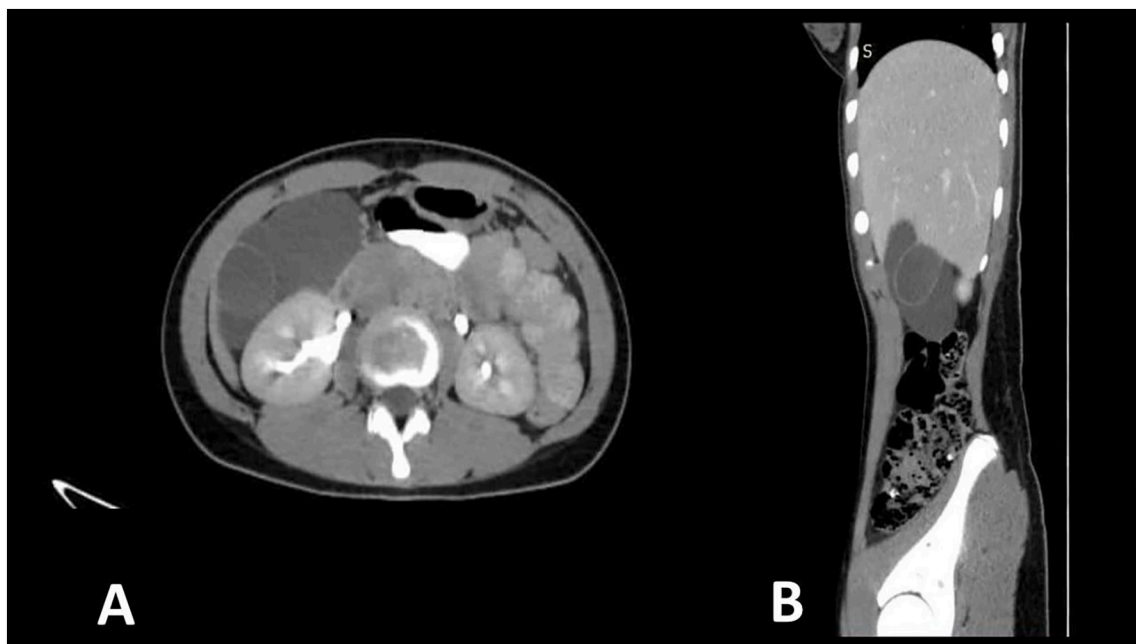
A: Axial CT scan showing large non-enhancing lesions, B: coronal CT scan with oral and IV contrast.
